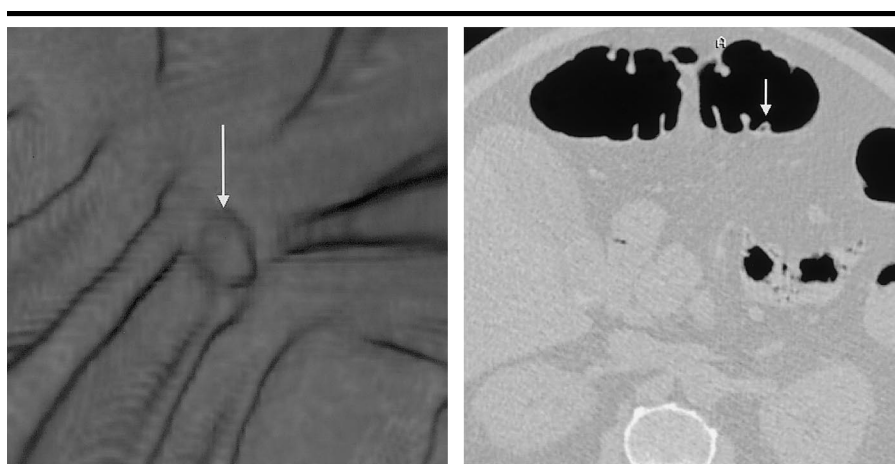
Internal area of hyperlucency in stool of 58-year-old man. (a) Three-dimensional volume-rendered endoluminal CT image shows a lobulated mass (arrow) suspected of being a polyp in the transverse colon. (b) Transverse CT colonographic image shows a tiny gas bubble in the center of the mass (arrow); this finding confirmed the presence of residual fecal material. No polyp was seen at colonoscopy.
